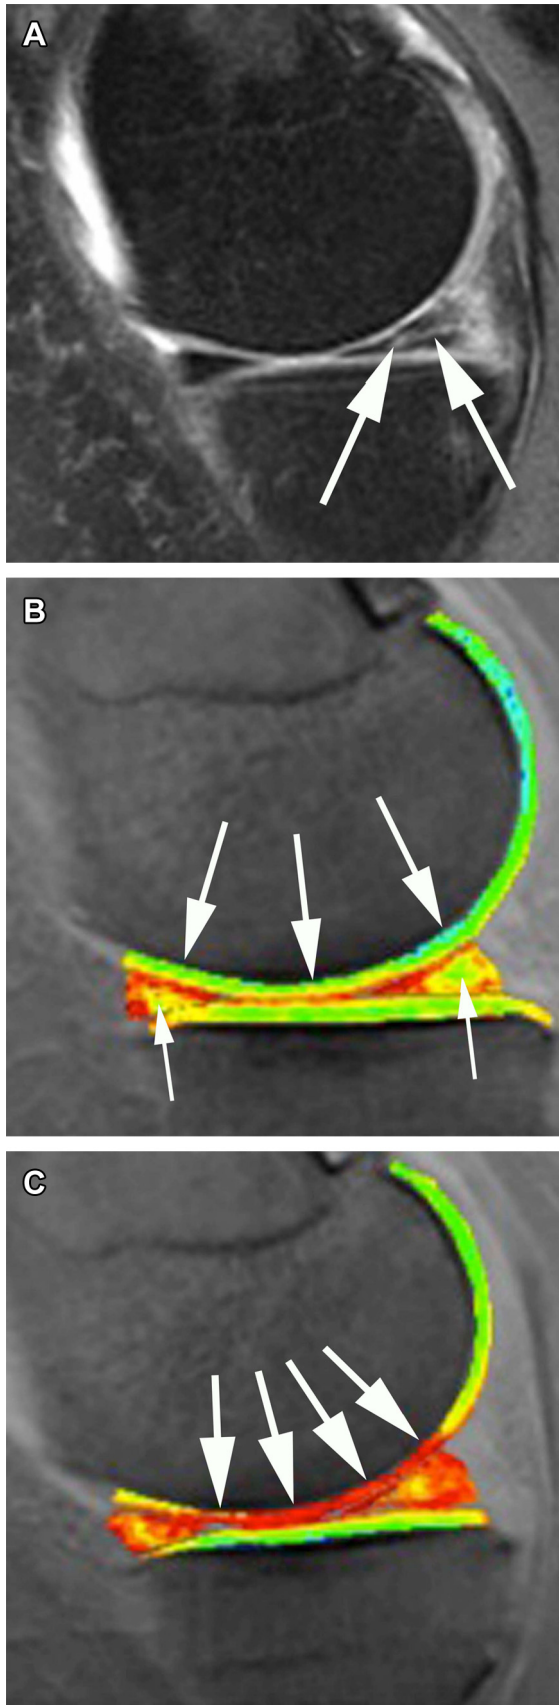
Compositional MRI of cartilage and meniscus over a 2-year period. A. Morphologic proton density-weighted fat suppressed image shows a horizontal-oblique tear of the posterior horn of the medial meniscus (arrows). B. Corresponding
